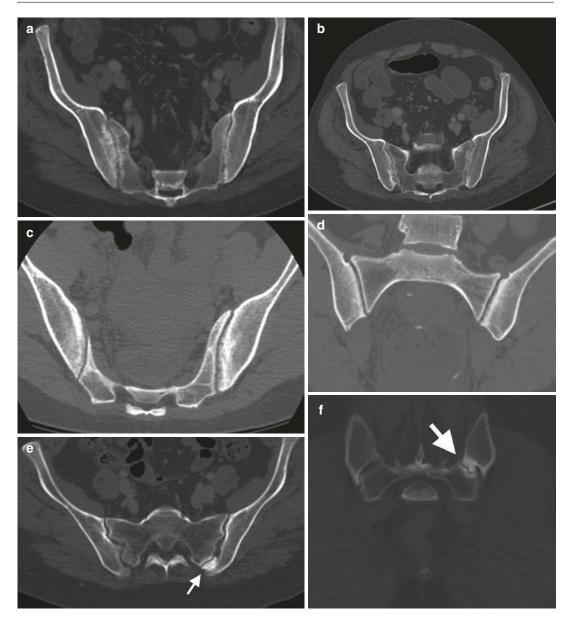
(a) A 31-year-old male with ulcerative colitis (UC). CT of the pelvis, bone windows, demonstrates bilateral sacroiliac joint space loss, erosions and mild subchondral sclerosis. CT performed for assessment obstruction (b) demonstrates dilated small bowel loops secondary
